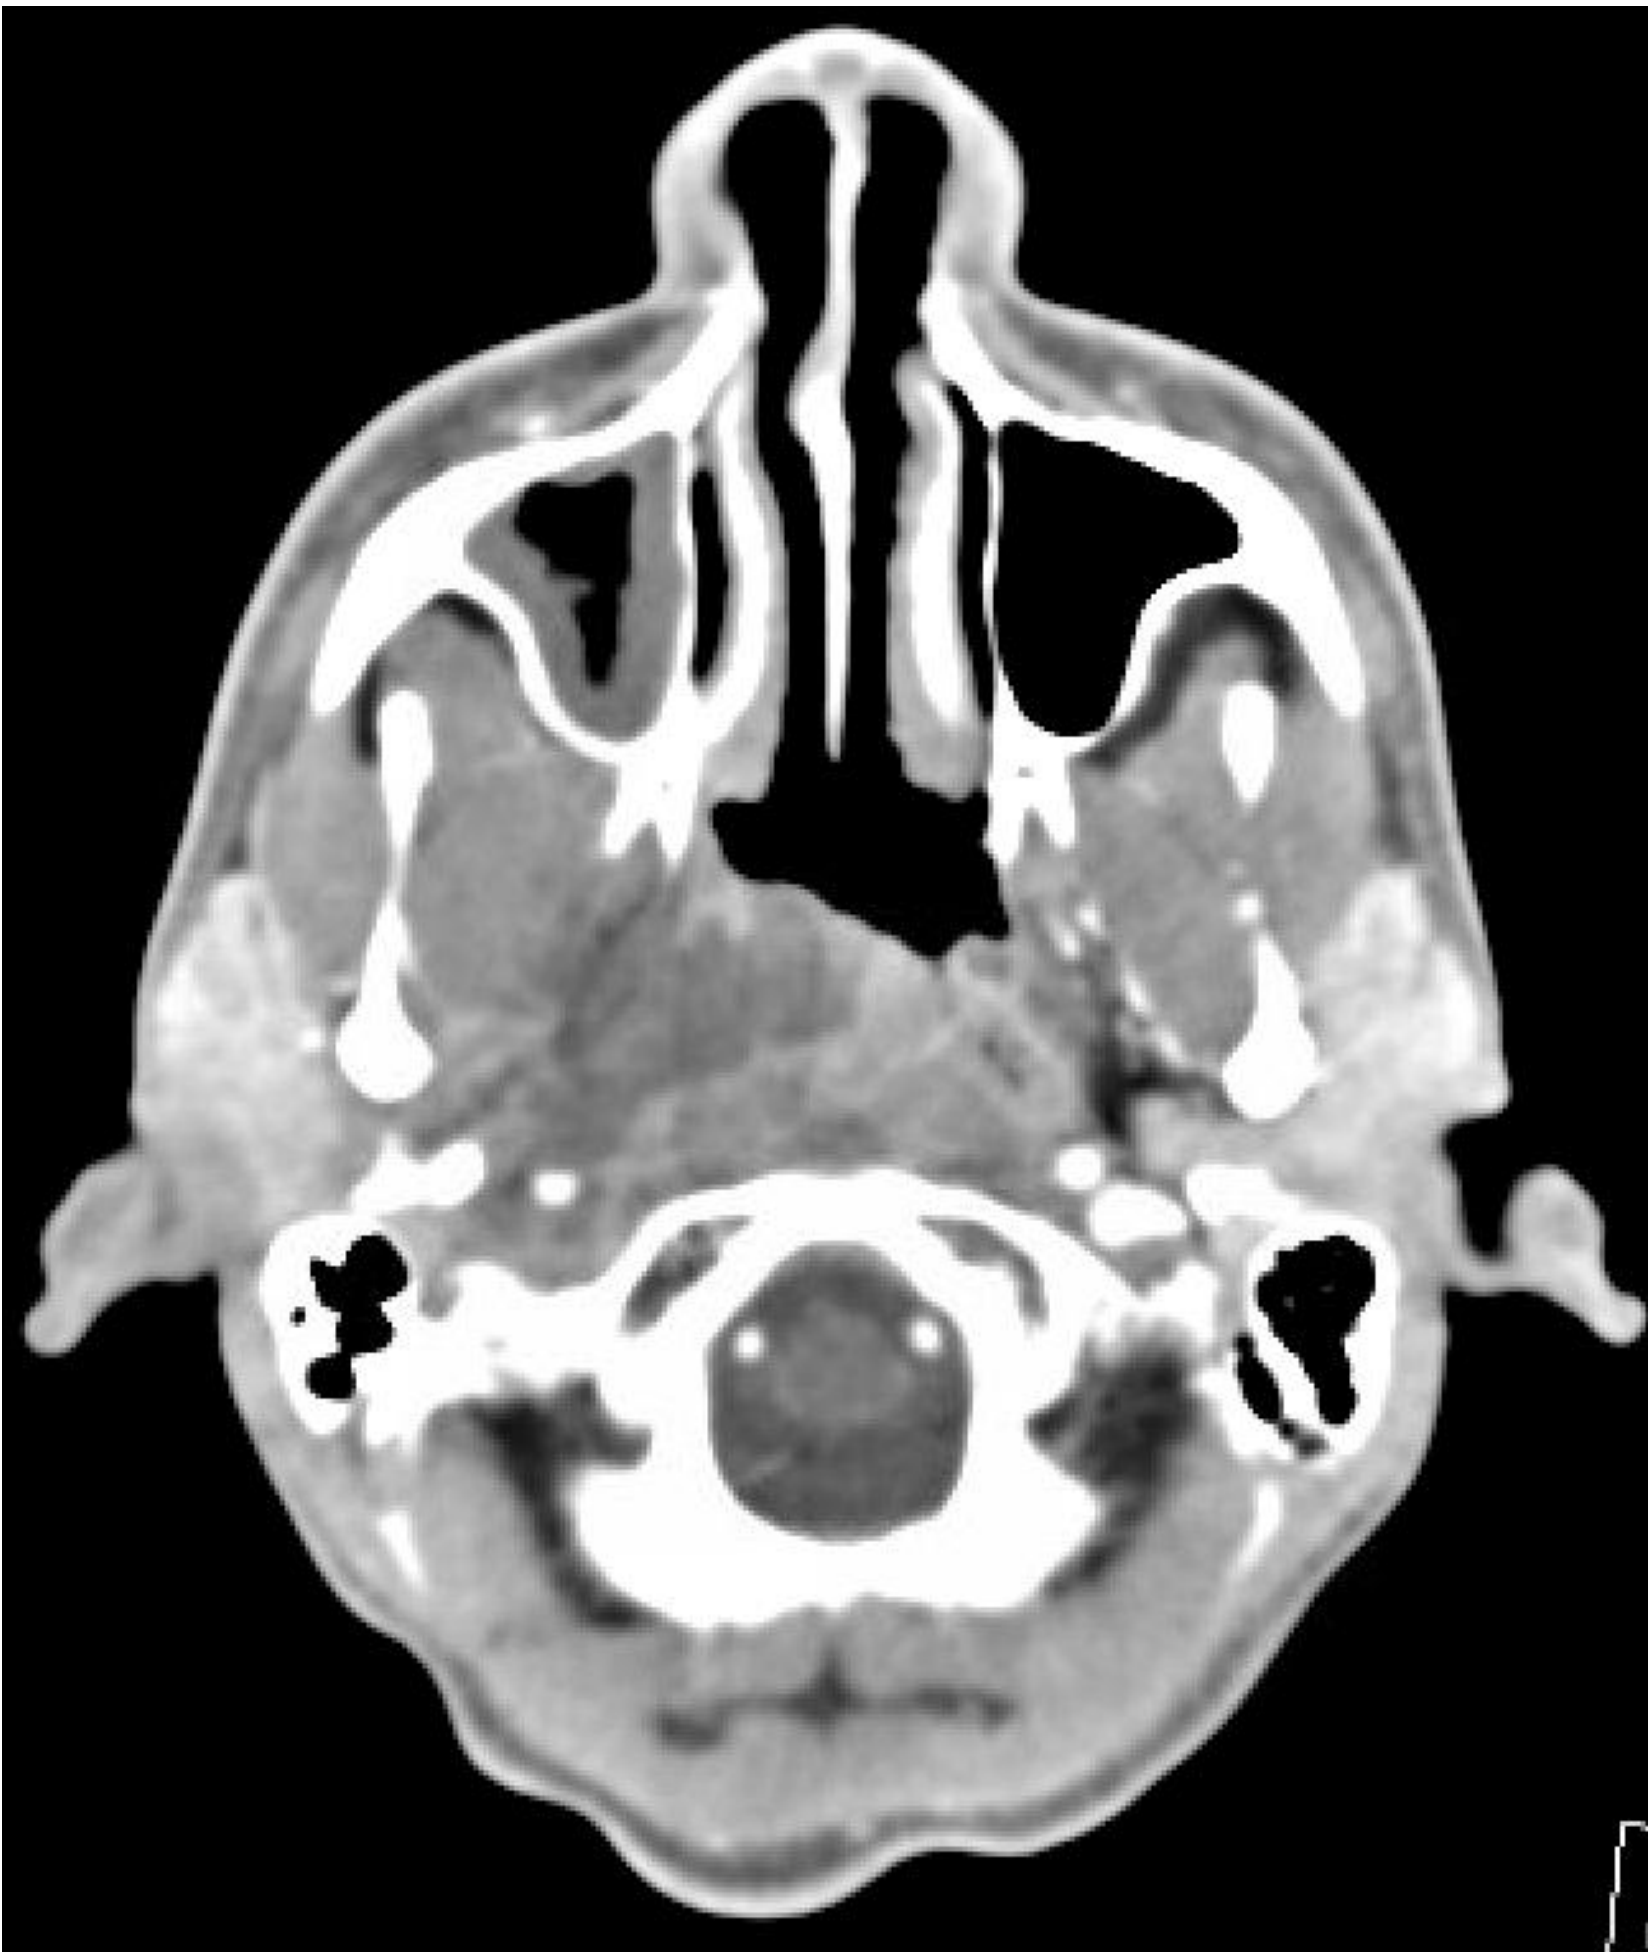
Computed Tomography (CT) Angiography of head and neck demonstrating extensive inflammation and hypoattenuation of the right parapharyngeal and retropharyngeal space. Occlusive spasm of right internal jugular vein.
